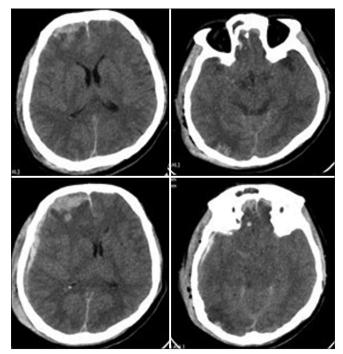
A 55-year-old male with Glasgow Coma scale (GCS) 12 on admission and computed tomography showing thin frontal subdural hematoma (SDH) and contusion with preserved basal cisterns (top panel). He deteriorated in GCS score with pupillary asymmetry and repeated scan showing worsening of the SDH and compressed basal cisterns (bottom panel).
